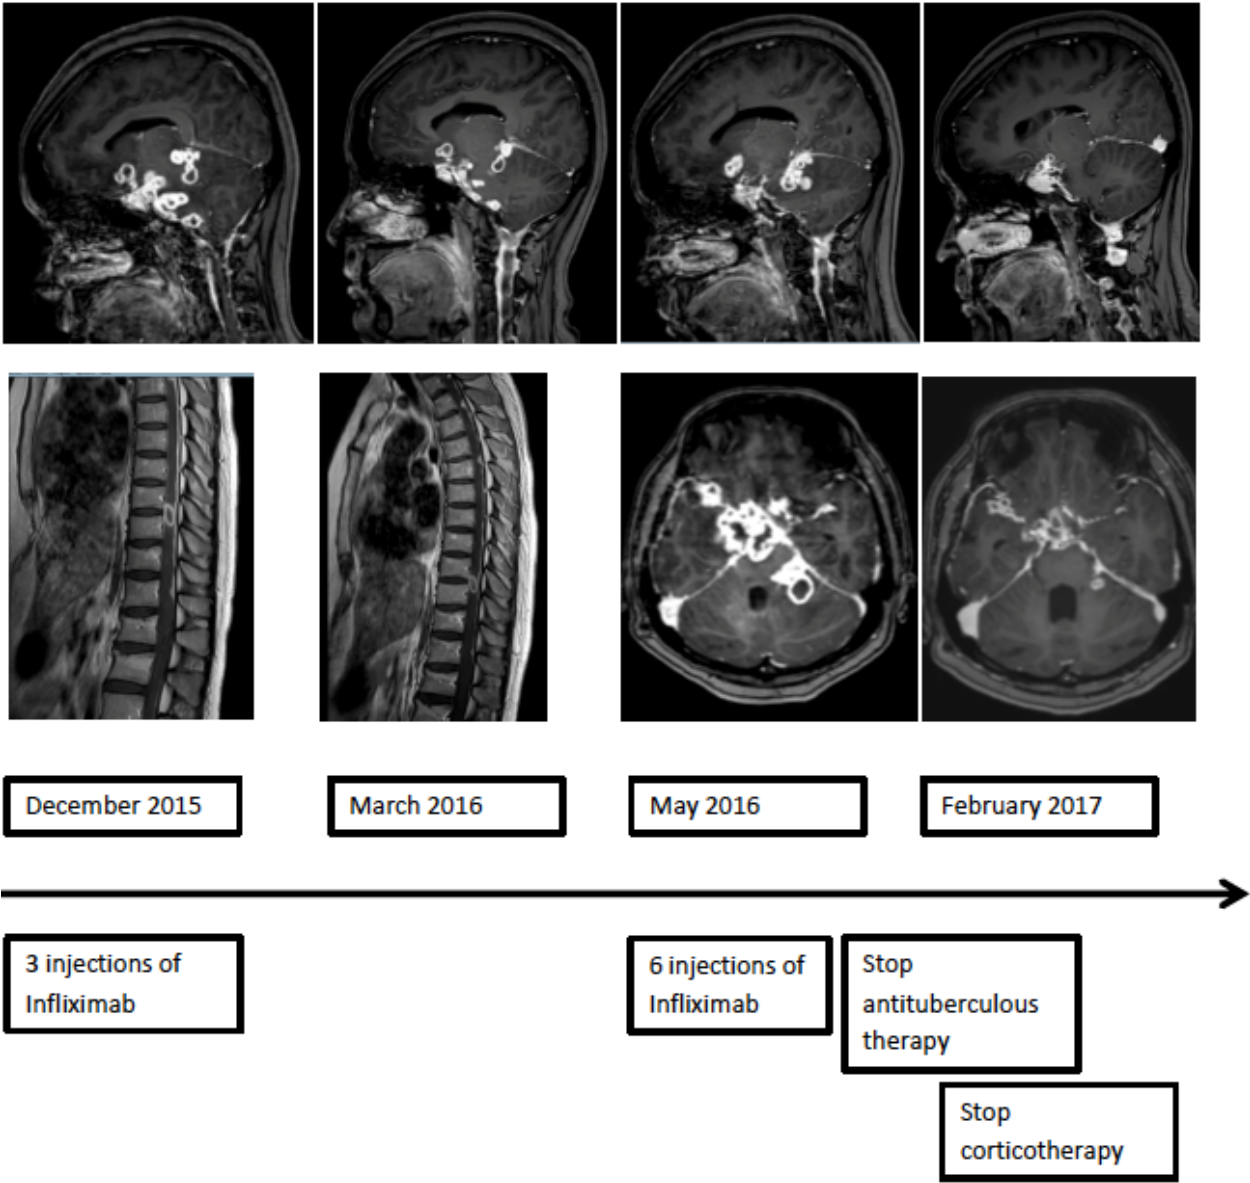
Case report #2: Evolution of cerebellar tuberculoma after 3 injections of infliximab. Sagittal gadolinium-enhanced T1-weighted sequences on magnetic resonance imaging.
